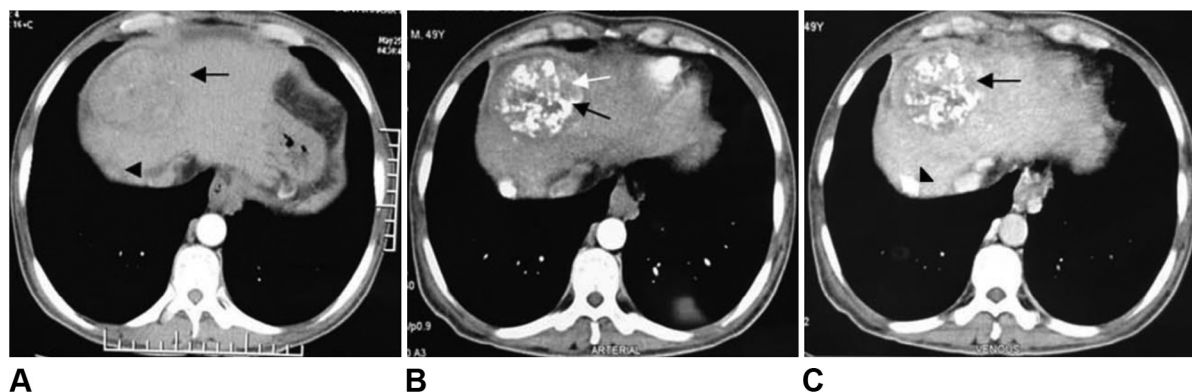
Pre TACE arterial phase CT image of the liver depicting two enhancing tumors, a large tumor in segment 8 (arrow) and a small tumor in segment 7 (arrow head). Patient was then subjected to TACE. Post TACE CT was done at 4 weeks. B) Arterial phase image showing inhomogenous dense lipiodol deposition in segment 8 (black arrow) and small areas of enhancement within the tumor (white arrow) which shows washout in the venous phase [arrow, (C)] suggestive of residual disease. The small segment 7 tumor shows complete coverage with dense lipiodol with no areas of enhancement in arterial and venous phase images B and C (arrow head), suggestive of complete response.
